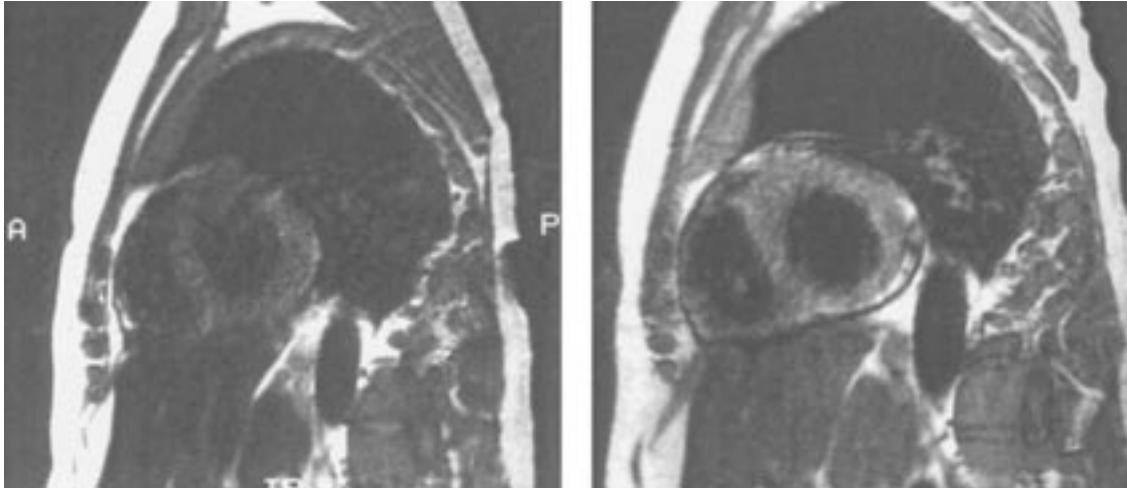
Sagittal T1-weighted spin-echo magnetic resonance image of the heart before (left) and after (right) therapy with the orally active iron chelator deferiprone. Inhomogeneity of the cardiac signal on the left is compatible with significant iron deposition, while improvements in signal intensity after 9 months of chelating therapy indicate a reduction in cardiac iron content.
